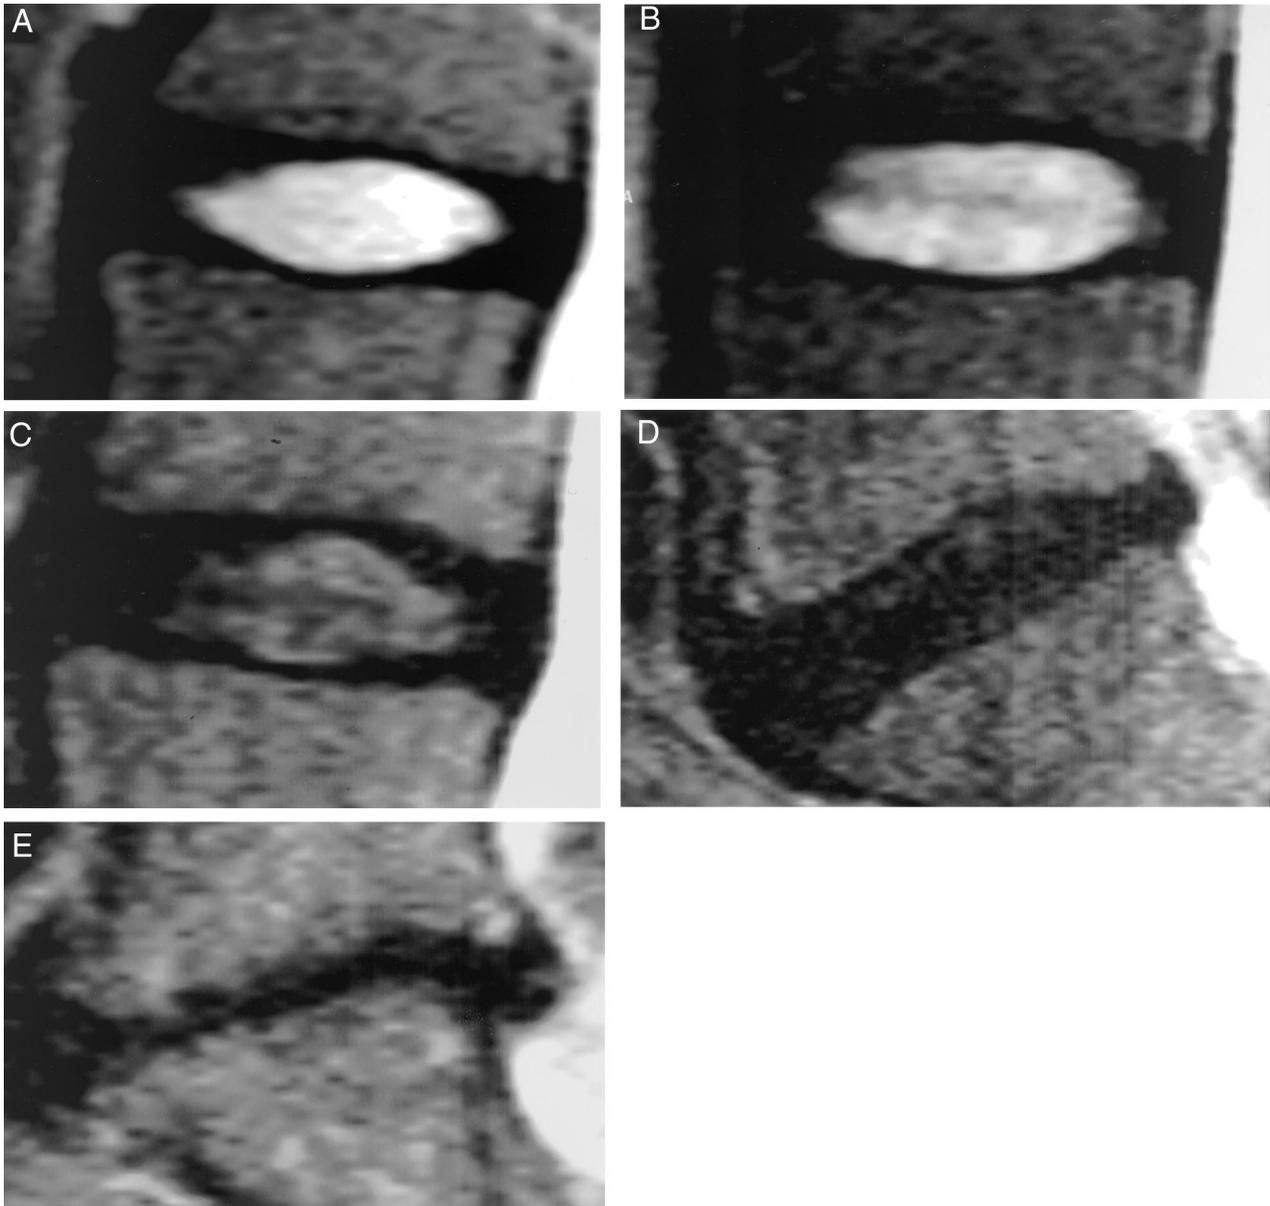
A–E, Grading system for the assessment of lumbar disc degeneration. Grade I: The structure of the disc is homogeneous, with a bright hyperintense white signal intensity and a normal disc height. Grade II: The structure of the disc is inhomogeneous, with a hyperintense white signal. The distinction between nucleus and annulus is clear, and the disc height is normal, with or without horizontal gray bands. Grade III: The structure of the disc is inhomogeneous, with an intermediate gray signal intensity. The distinction between nucleus and annulus is unclear, and the disc height is normal or slightly decreased. Grade IV: The structure of the disc is inhomogeneous, with a hypointense dark gray signal intensity. The distinction between nucleus and annulus is lost, and the disc height is normal or moderately decreased. Grade V: The structure of the disc is inhomogeneous, with a hypointense black signal intensity. The distinction between nucleus and annulus is lost, and the disc space is collapsed. Grading is performed on T2-weighted midsagittal (repetition time 5000 msec/echo time 130 msec) fast spin-echo images.
